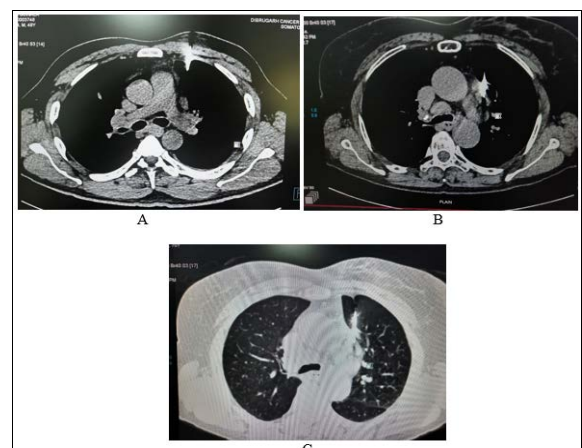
a, b, c: Showing CT guided biopsy of a prevascular station lymph node, transpulmonary approach.
